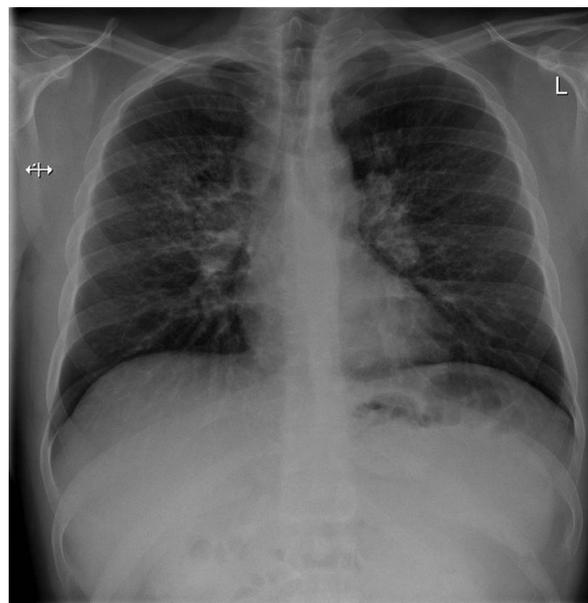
Chest X-ray of the patient with stage II sarcoidosis. Enlarged bilateral hilar lymph nodes, widening of mediastinum and bilateral nodular shadows spreading from perihilar regions to the lung periphery
